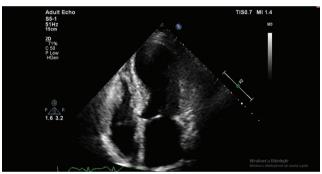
Transthoracic echocardiography demonstrated apical ballooning of the left ventricle.
